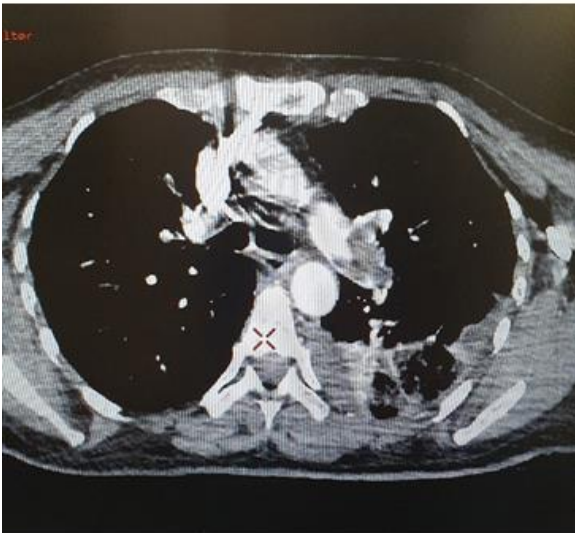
CT angiography on admission
